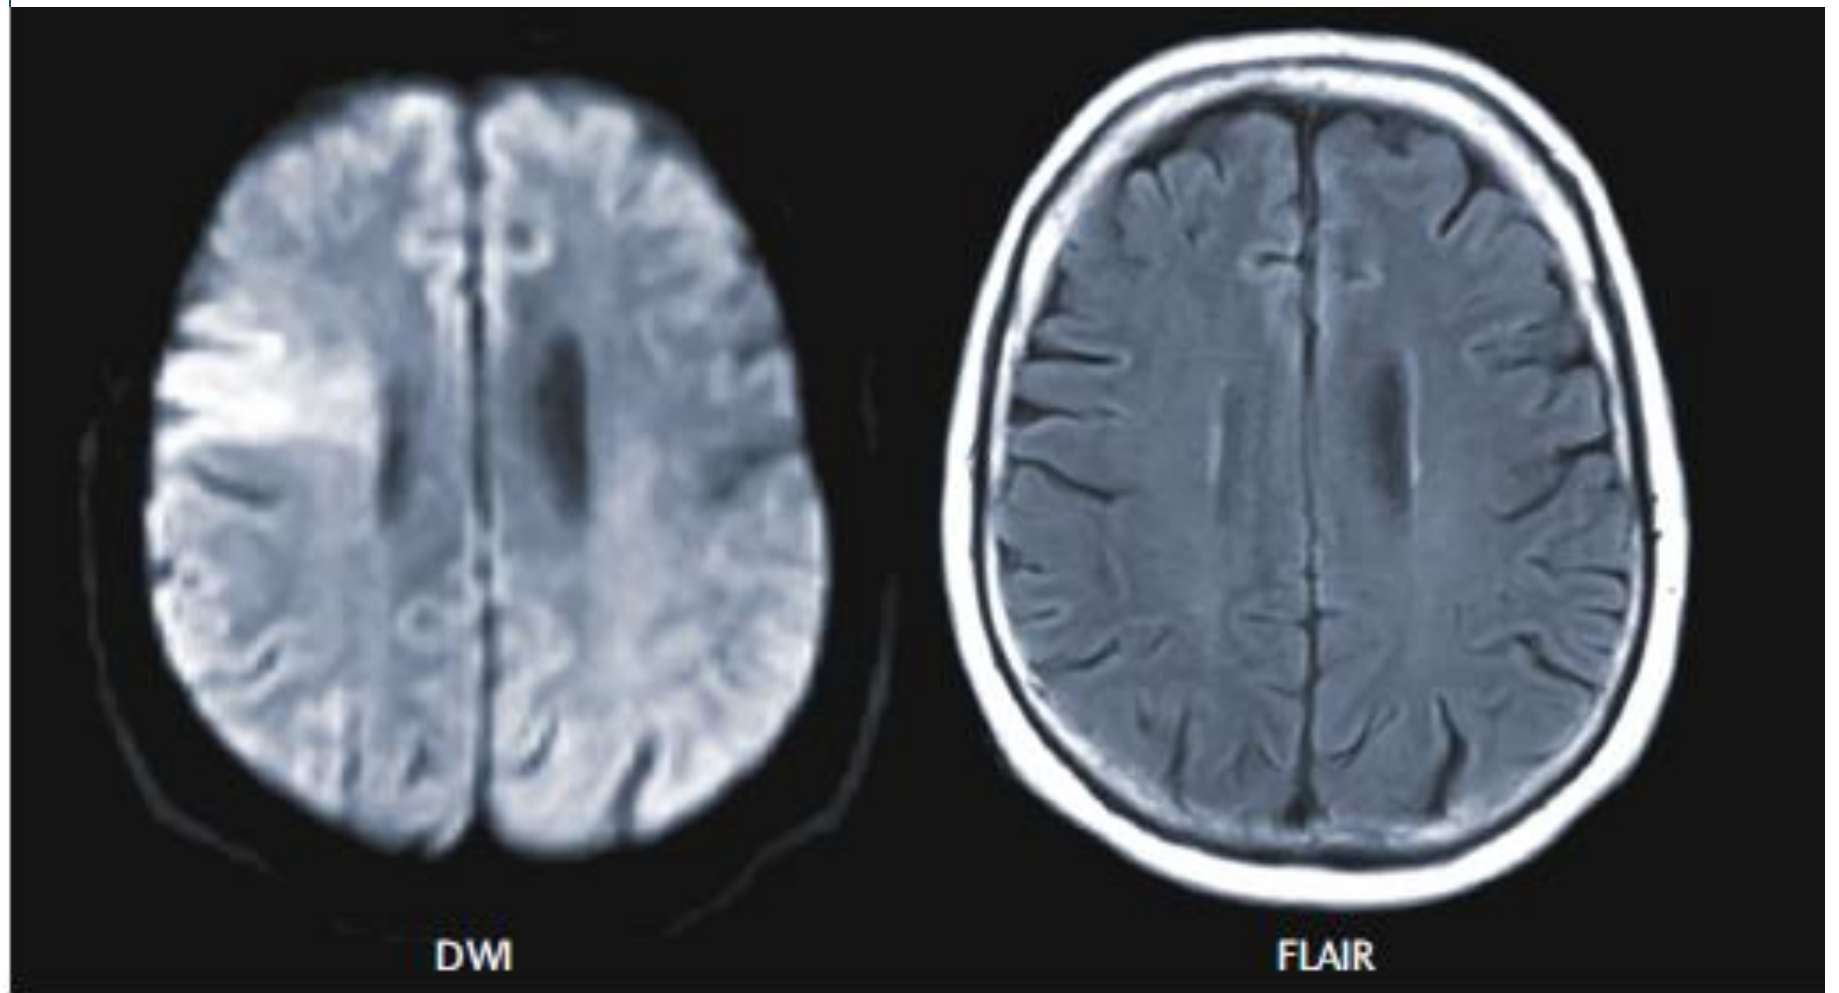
The imaging mismatch between diffusion-weighted imaging (DWI) and fluid attenuation inversion recovery (FLAIR) imaging that indicated a probable benefit of thrombolysis in the WAKE-UP trial. Image courtesy of Götz Thomalla, University Medical Center Hamburg-Eppendorf, Germany.
